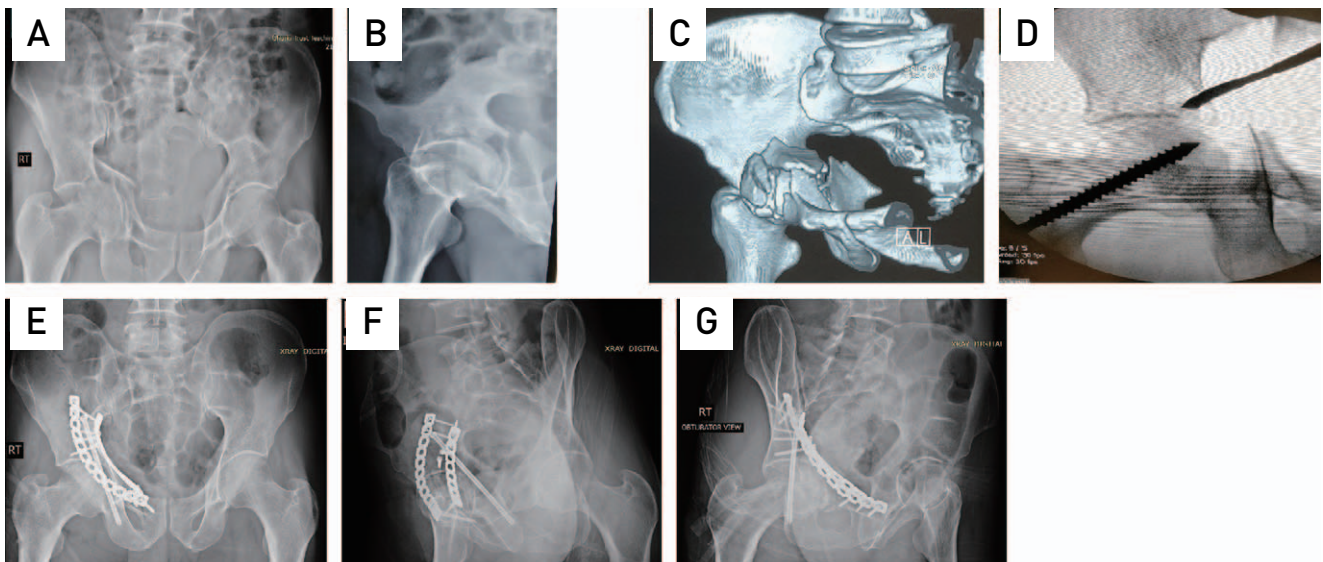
A 51-year-old male sustained pelvic trauma in a road traffic accident. Preoperative x-rays show low anterior column and posterior hemitransverse fracture with a positive Gull sign of superomedial dome impaction. Computed tomography (CT) scan shows comminuted fractures of the anterior column/wall and quadrilateral plate. Intraoperative fluoroscopic views demonstrate articular dome disimpaction and autografting. Postoperative images show fixation with a suprapectineal plate plus infrapectineal buttress plating for a quadrilateral plate and antegrade posterior column screw via a small lateral window. (A) X-ray pelvis anteroposterior (AP) view. (B) X-ray pelvis iliac oblique view. (C) CT scan with 3D reconstruction. (D) Intraoperative fluoroscopic view. (E-G) Immediate postoperative X-ray pelvis AP, iliac oblique and obturator oblique views.
